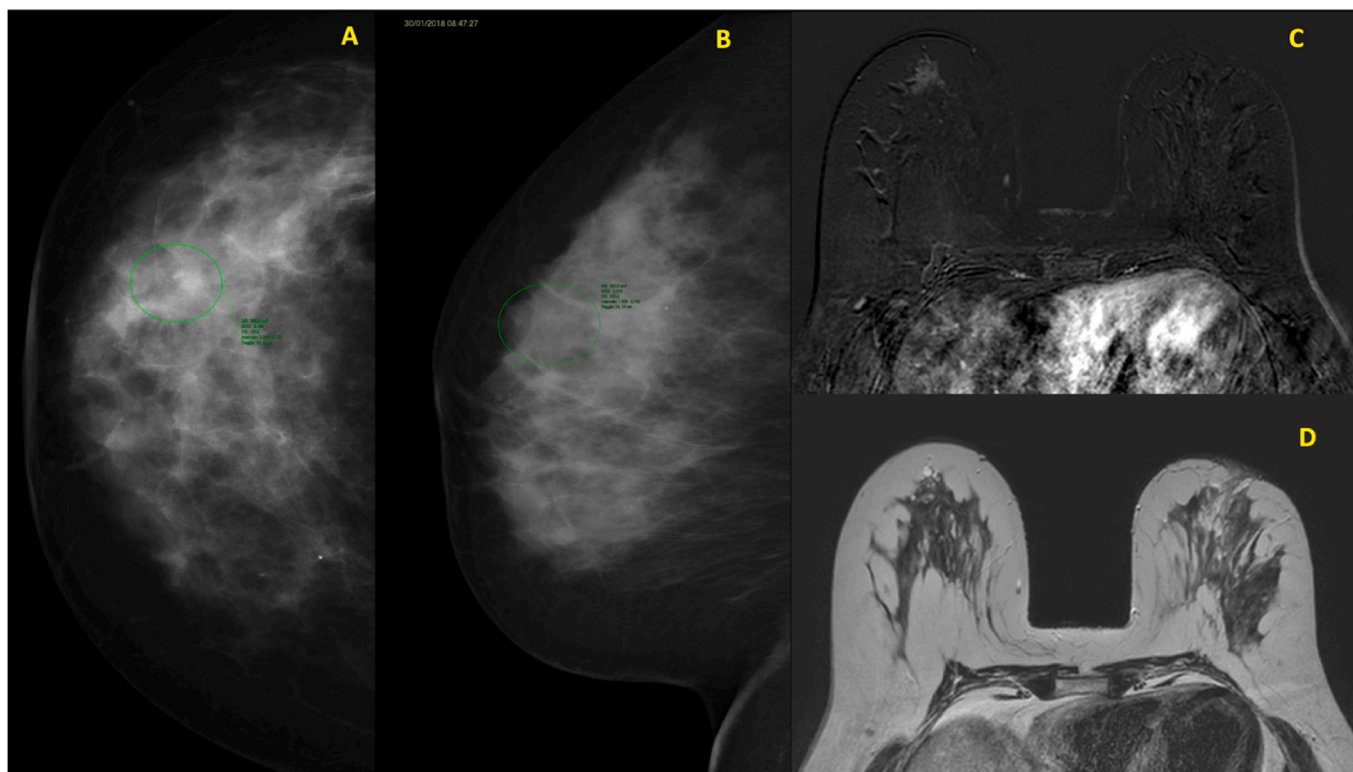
CEM and MRI for DCIS
